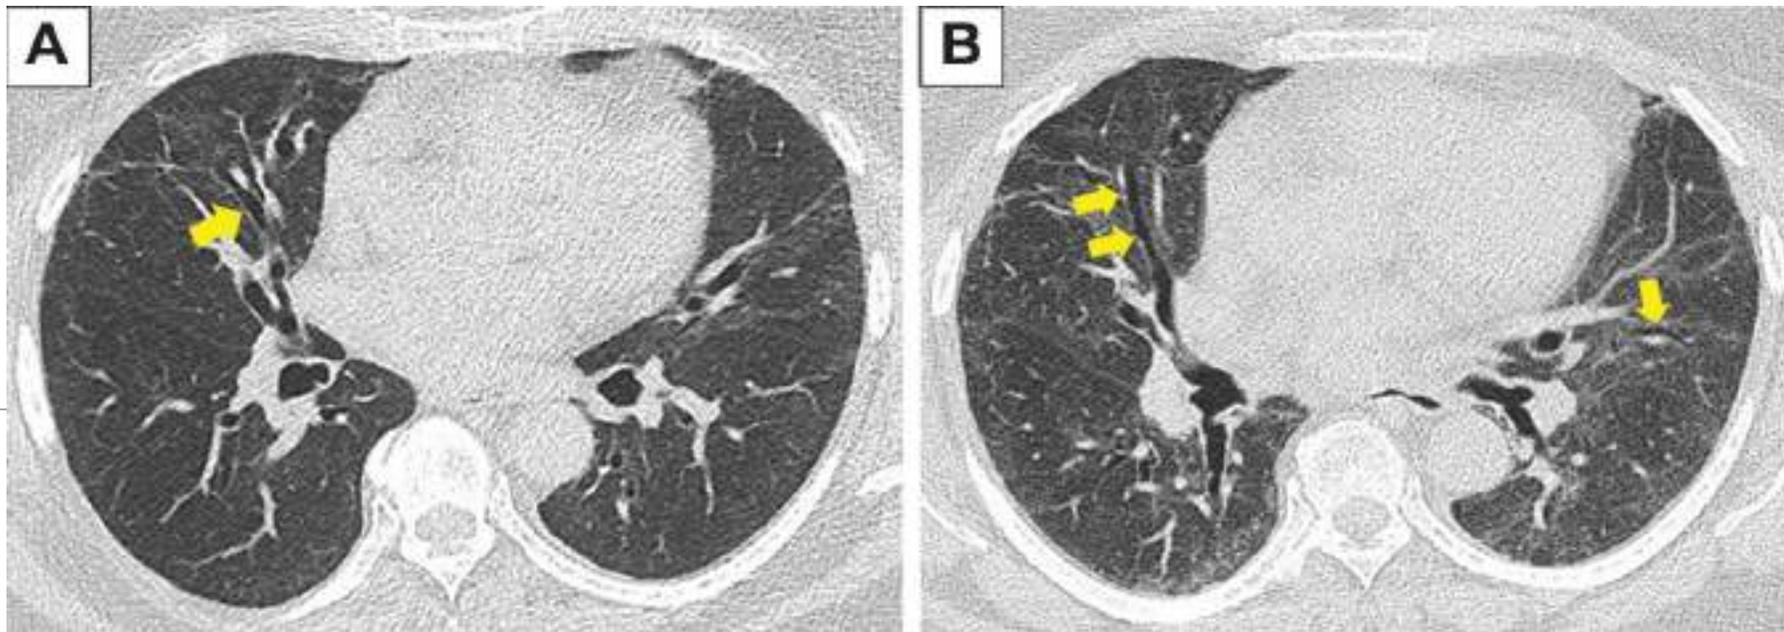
Paired axial unenhanced CT scans in a 59-year-old man at (A) 3 months and (B) 1 year after hospital discharge for COVID-19. Images show widespread residual bilateral ground-glass opacification, a few band opacities, and, importantly, evidence of traction bronchiectasis in the middle and left lower lobes (arrow in A) at 3 months. There is a reduction in the extent of ground-glass opacification and bands but with persistent traction bronchiectasis (arrows in B) at 1-year follow-up.
